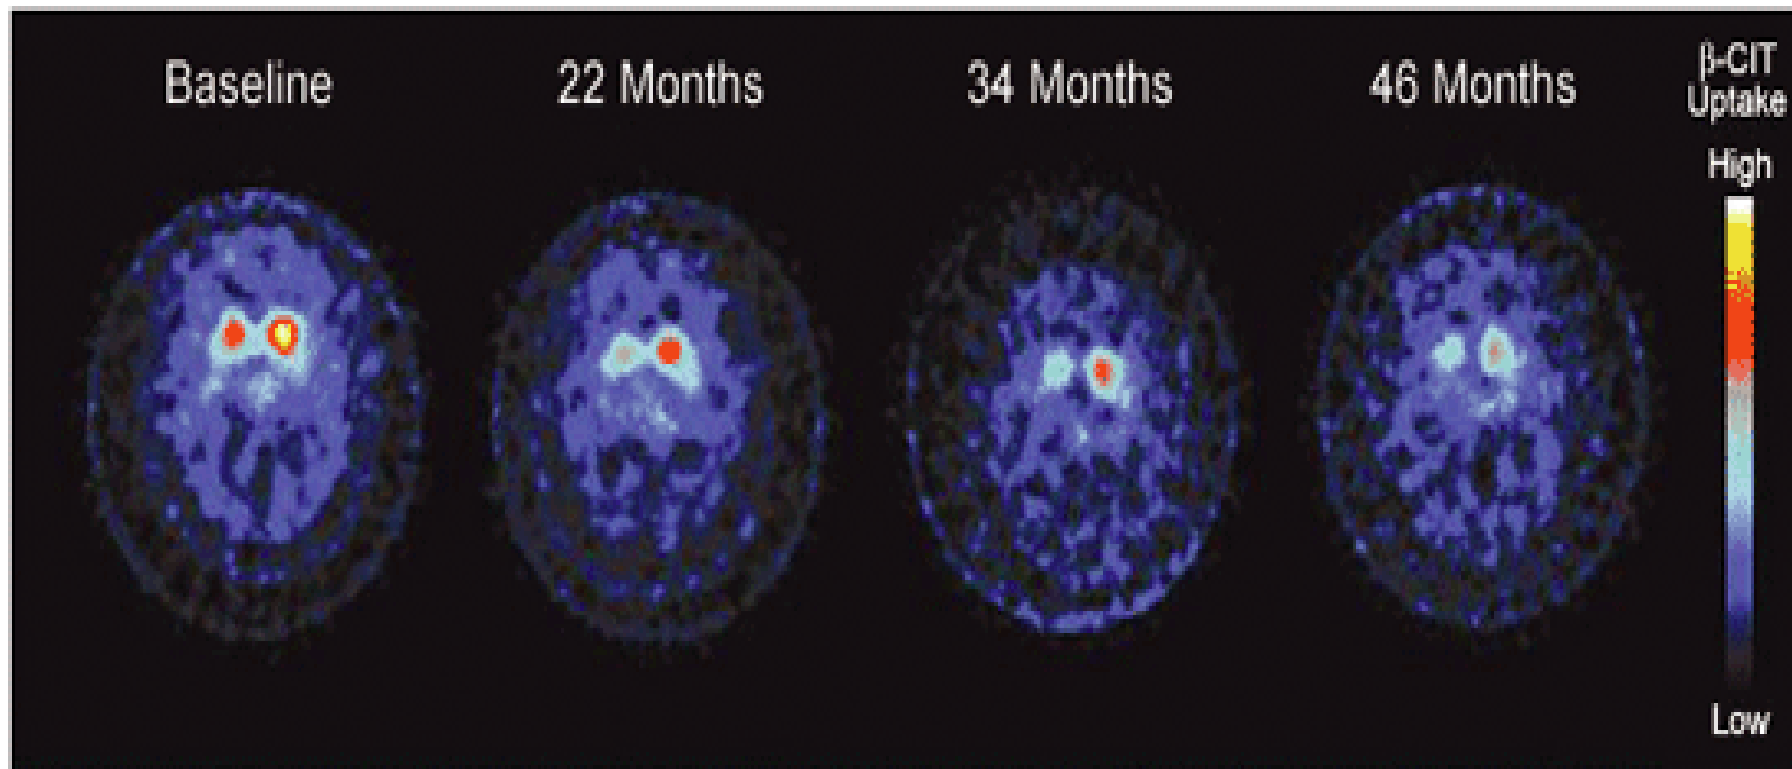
SPECT images show progressive decline of nigro-striatal DAT function.
